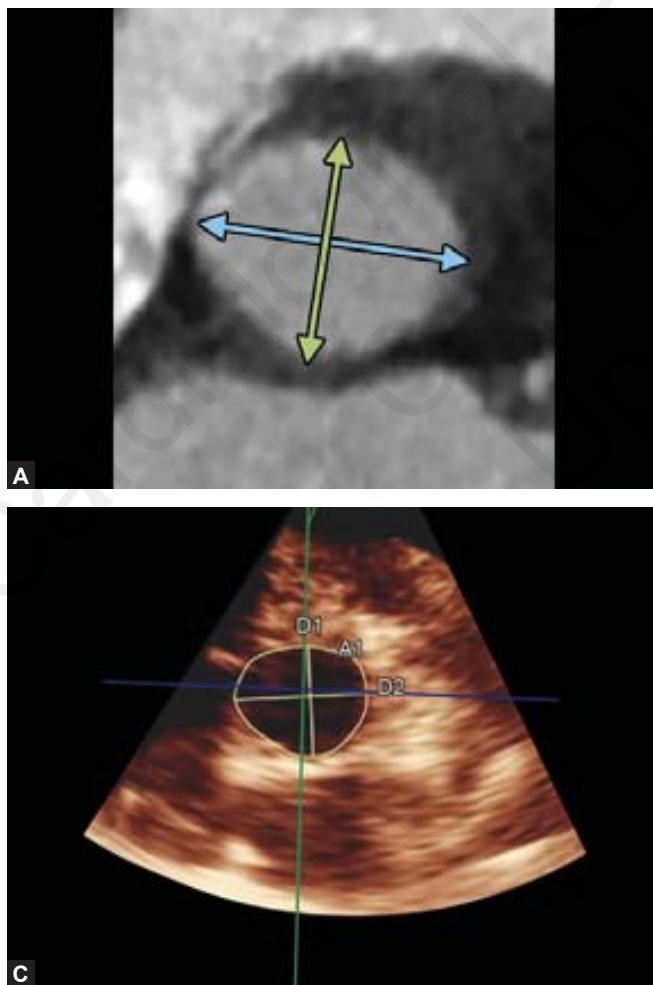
Advantage of three-dimensional echocardiography for measurement of left ventricular outflow tract (LVOT) area. A, Computed tomography reveals oval shape of the LVO; B, Single measurement in two-dimensional imaging is likely to underestimate LVOT area; C, Three-dimensional echocardiography permits measurement of true LVOT area.
